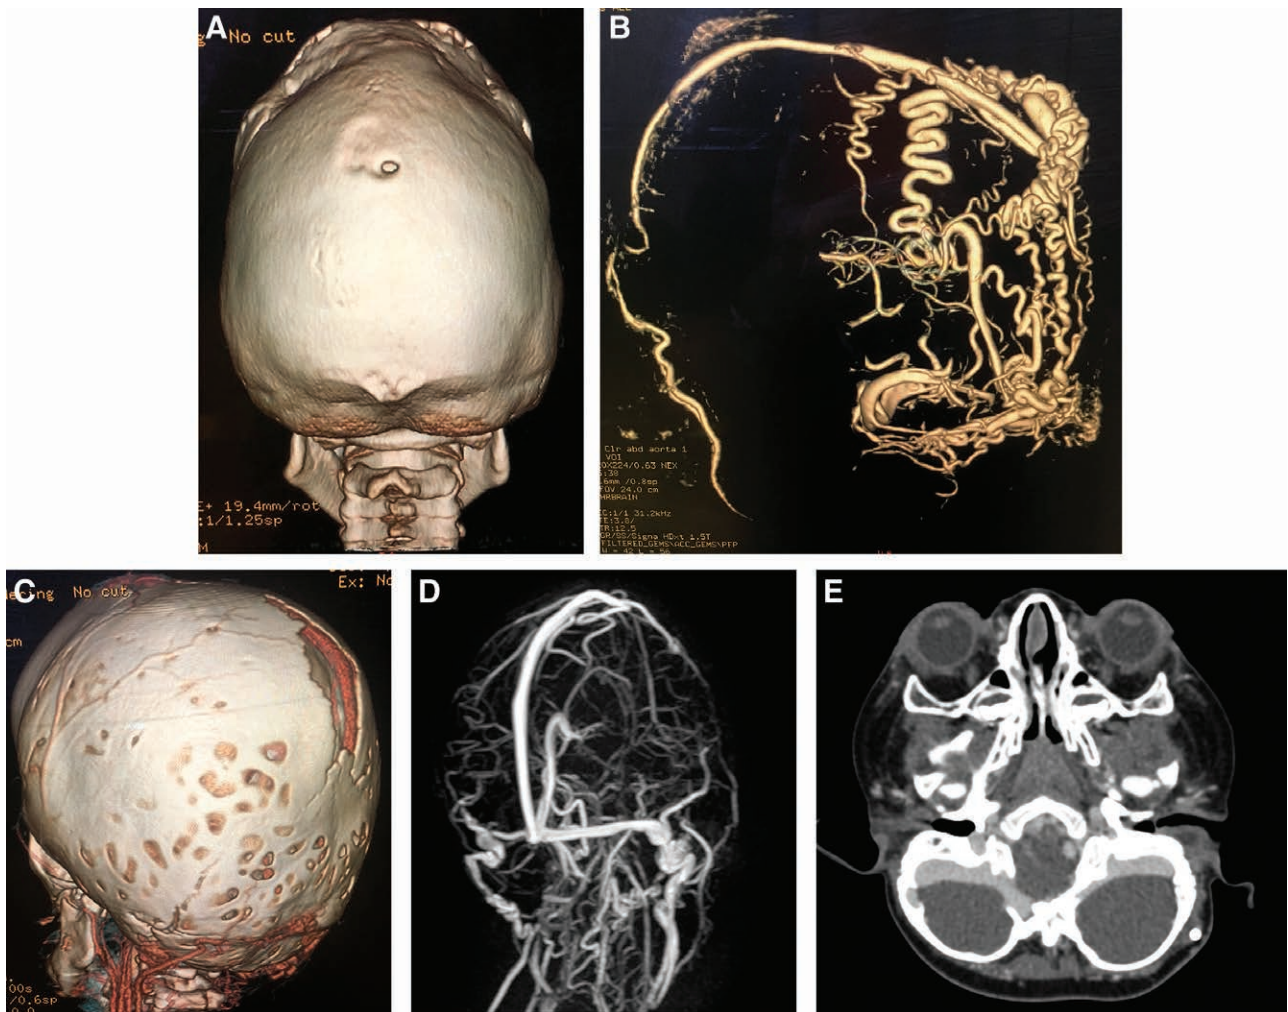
Representative images of venous anomalies. A, CT scan of an 8-year old male with Crouzon syndrome demonstrating a small innocuous foramina in the midline. B, CT venogram of the same patient showing extensive subcutaneous venous plexus draining from the sagittal sinus in the same patient. C, Emissary veins in the occipital region in a 9-month old female with Pfeiffer syndrome. D, MR venogram showing retrosigmoid emissary veins and jugular foramen stenosis. E, Axial CT venogram demonstrating occipital sinus and jugular stenosis.
